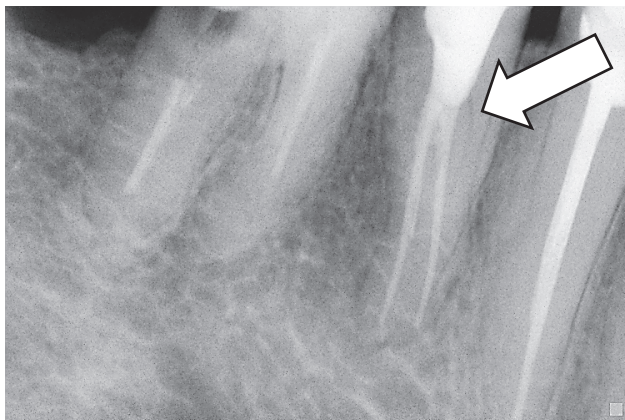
Control radiograph. A third canal was observed (white arrow) after the distobuccal and mesiobuccal root canals were obturated.
